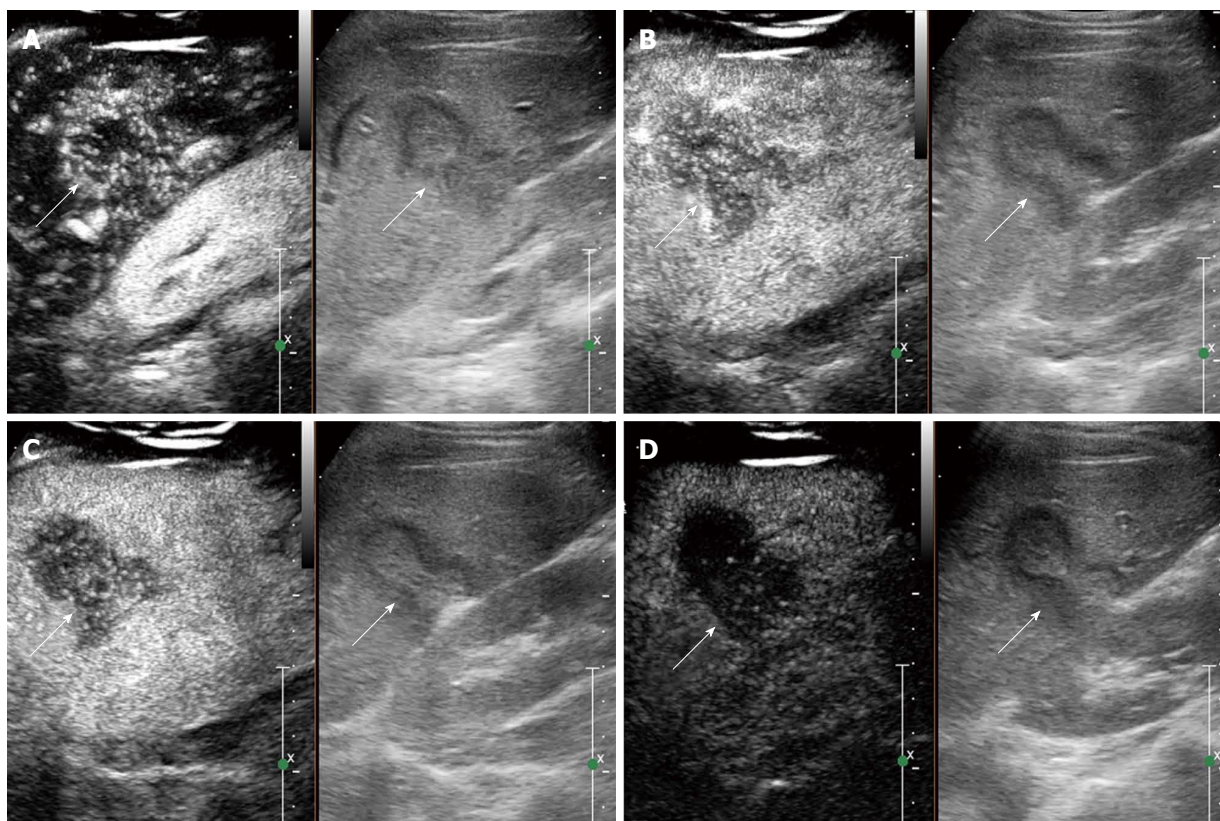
Contrast-enhanced ultrasound feature of hepatic epithelioid hemangioendothelioma in a 25 year female. A: Heterogeneous enhancement pattern. In the arterial phase (16 s after injection of SonoVue), the lesion showed heterogeneous enhancement; B: The enhancement gradually decreased (22 s after injection of SonoVue); C: In the portal venous phase (40 s after injection of SonoVue), the lesion washed out fast than the liver parenchyma and showed hypoenhancement. D: In the late phase (165 s after injection of SonoVue), the lesion remained hypoenhanced.
